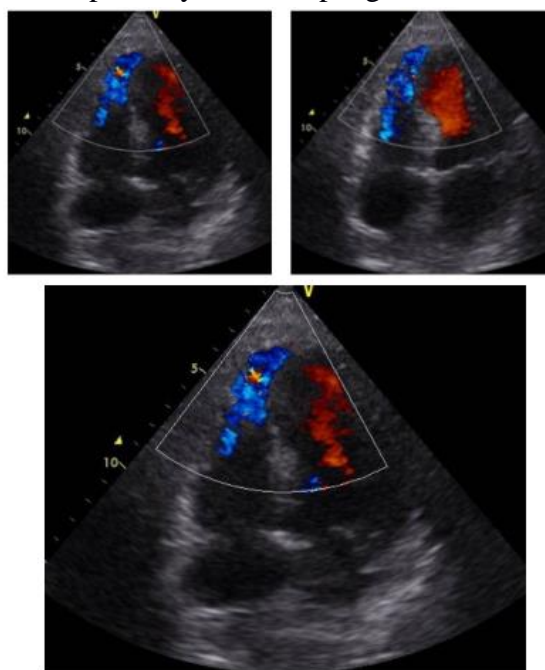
Echocardiogram performed in the ICU in the 4th day post operatory. Amplatzer device properly implemented, suitable size of the left ventricle, LVEF 40-50%, and mild mitral insufficiency.
